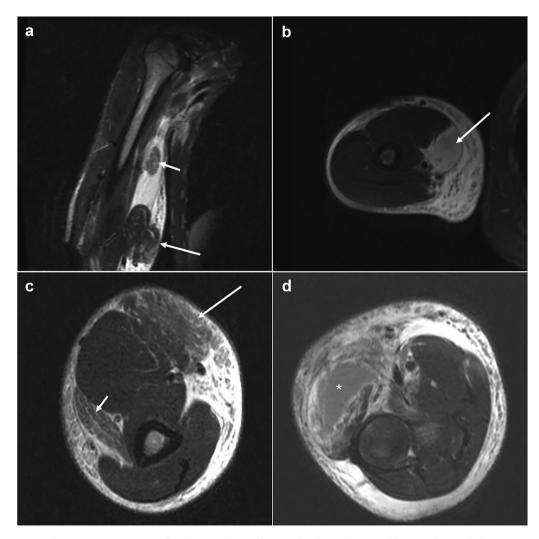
(a) MRI coronal image demonstrating transections of the short head biceps (*long arrow*) and coracobrachialis (*short arrow*) muscle bellies with proximal defect and distal retraction and folding over of the biceps; Cor FSEIR TR 4000/TE 36. (b) MRI axial image demonstrating defect (*arrow*) due to retraction of the short head biceps muscle belly; AX FSE T2FS TR 3000/TE 58. (c) MRI axial image demonstrating retracted biceps short head muscle bulging medially (*long arrow*) and partial tearing of brachioradialis muscle (*short arrow*); AX FSE T2FS TR 3000/TE 68. (d) MRI axial image demonstrating extensor carpi radialis longus muscle belly hematoma (*); AX FSE T2FS TR 3000/TE 68. *MRI*, magnetic resonance imaging; *Cor*, coronal; *FSEIR*, fast spin echo inversion recovery; *TR*, time to repetition; *TE*, time to echo; *AX*, axial; *FSE*, fast spin echo; *T2FS*, T2-weighted fat-saturated.
